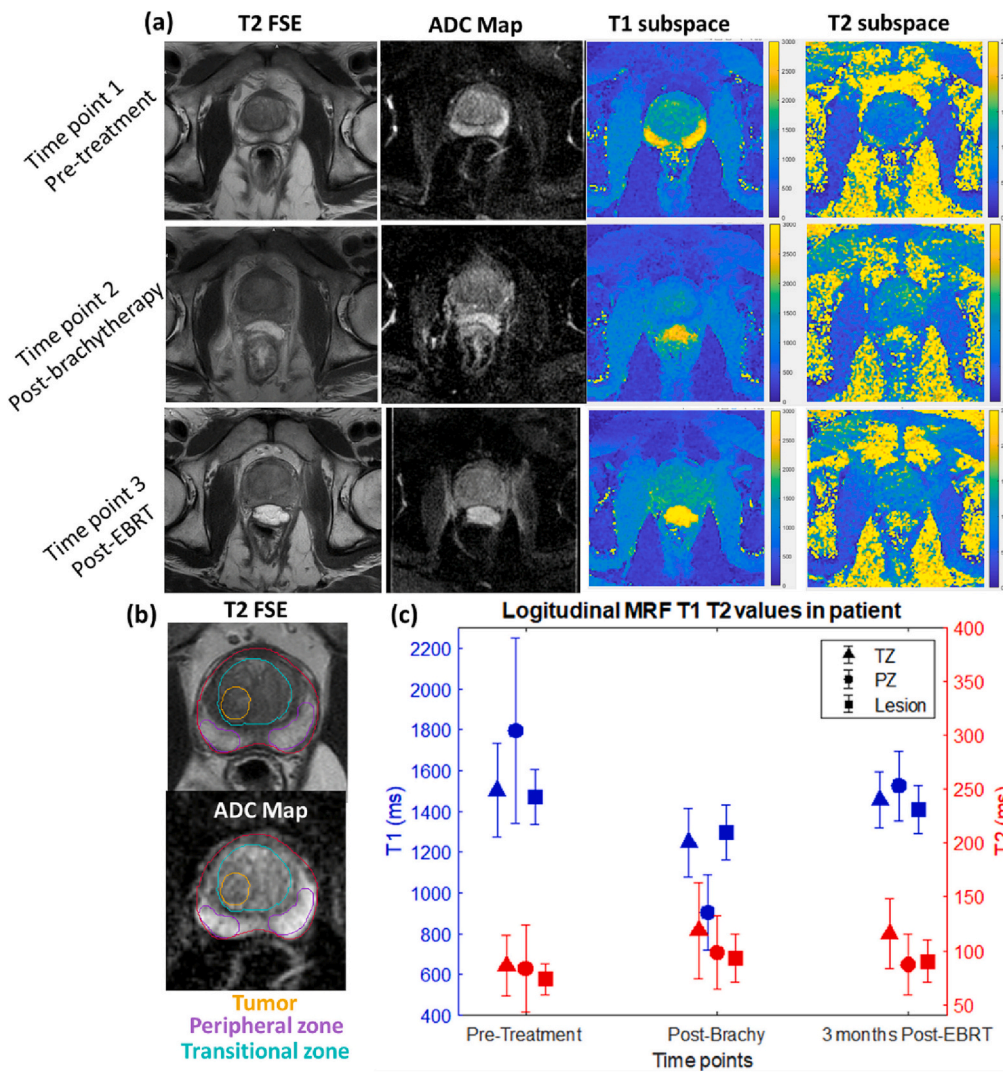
Tissue maps obtained from patient 2 (64-year old) with a 1.4 cm lesion involving the anterior apex of the transitional zone without extracapsular extension. (a) T2-weighted imaging, ADC maps, T1/T2 maps acquired with subspace reconstruction for all three time points (b) contour definition of tumor, PZ, and TZ overlaid on T2 FSE and ADC maps from the pre-treatment time point. (c) The mean \pm SD T1 and T2 values in each region plotted over time to demonstrate longitudinal changes following two types of radiation treatments.
